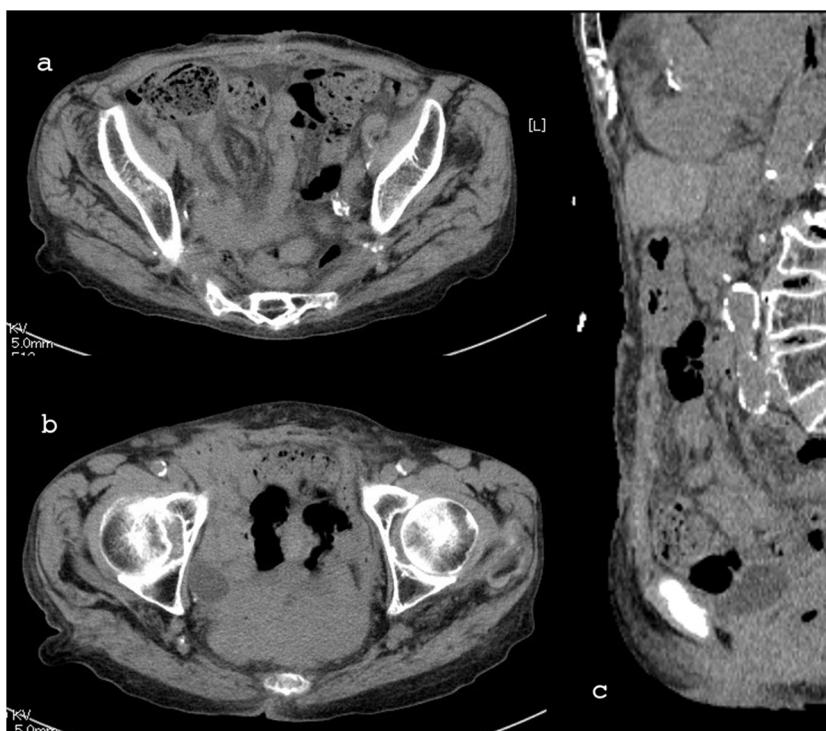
Postoperative CT scan 3 months after the procedure shows complete repair of the abdominal wall. No hernial recurrence is evident in any area. (a) Fixation of the large incisional hernia. (b) Repair of the bilateral inguinal hernias. (c) Saggital section of the center.
